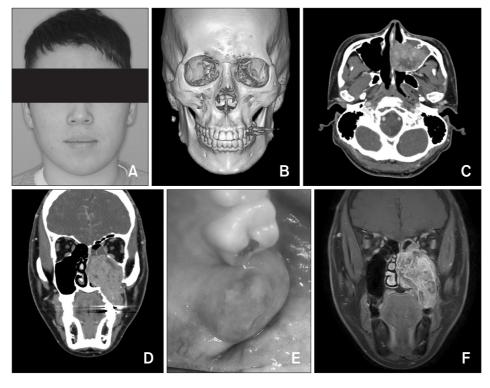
(A) Patient's facial photograph. No significant facial deformities were present. (B) Three-dimensional computed tomography (CT) view. (C) Axial view in enhanced CT. (D) Coronal view in enhanced CT. (E) The tumor perforated the left second molar area mucosa and protruded into the oral cavity. (F) Coronal view in magnetic resonance imaging showed mucosal thickening at the patient's left ethmoidal sinus and the thickened mucosal margin had a boundary with the mass.
